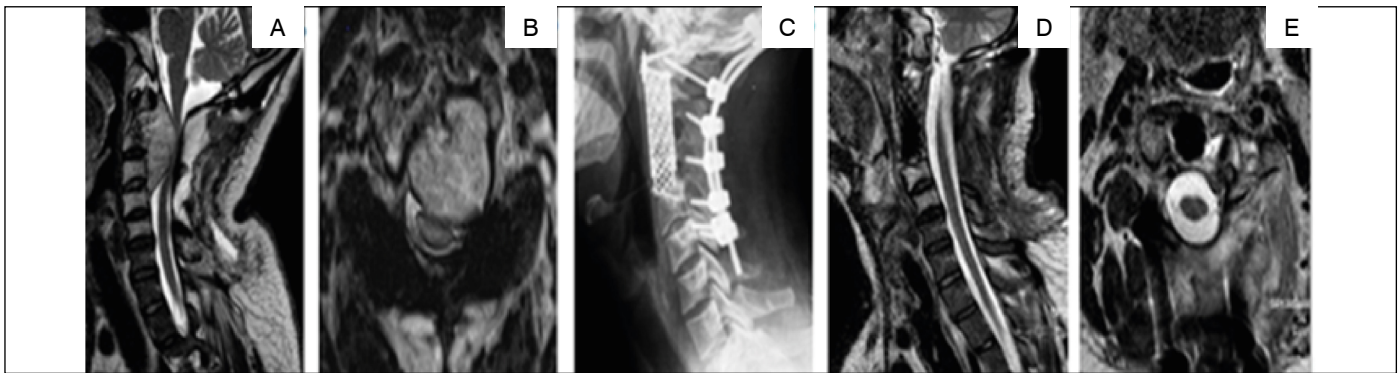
(case 3): A and B – T2 MRI showing a huge recurrent extradural lesion from C1-C4. C – Anterior reconstruction after tumoral removal. D and E – T2 MRI showing no residual tumor and medullary decompression.
